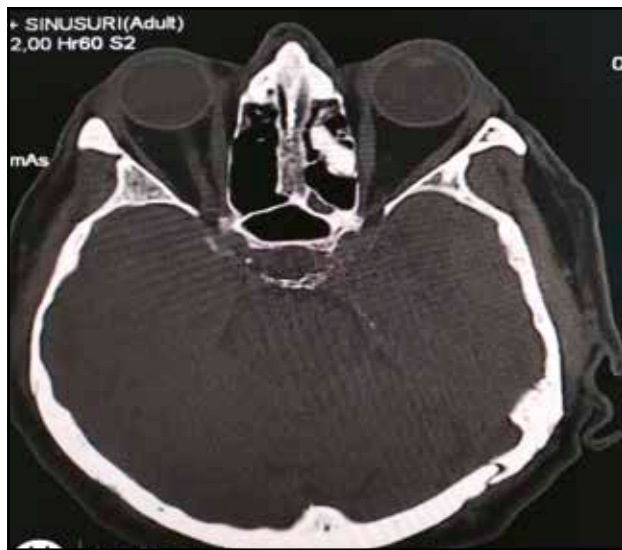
Cranio-facial CT scan (performed in 2025, prior to surgery) – association of fungal sinusitis with involvement of the left posterior ethmoid cells on the same side as the tumor.
